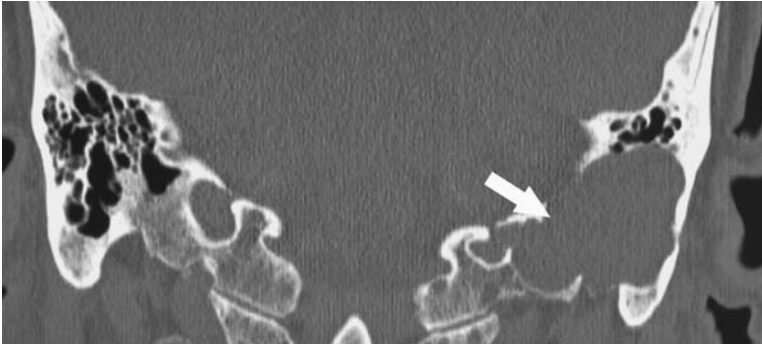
(Patient 1) Computed tomographic (CT) scan shows that lesion has exposed superolateral surface of jugular bulb (arrow).
